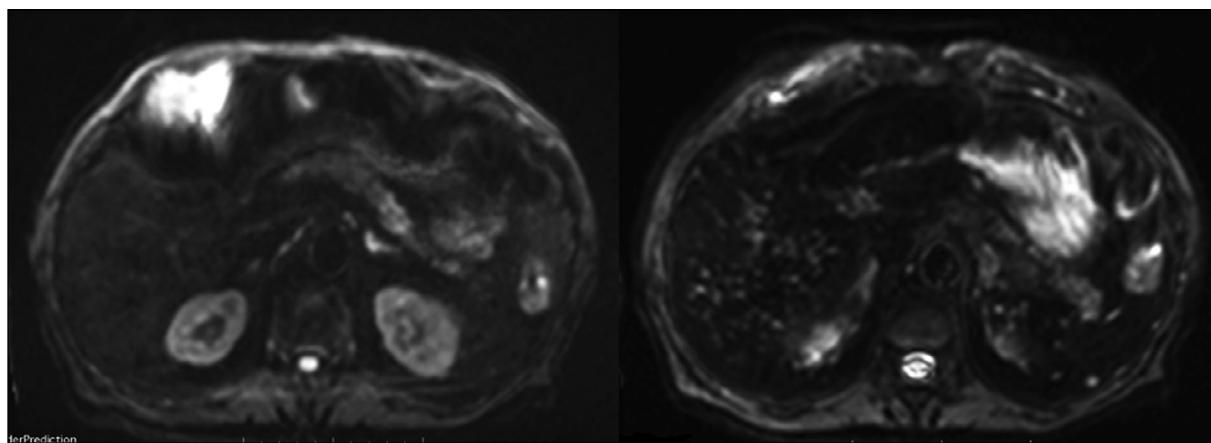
Axial MRI image with DWI sequence: hyperintense lesions at low B-value (50 sec/mm^2) on the right, disappearing at high B-values (800).
